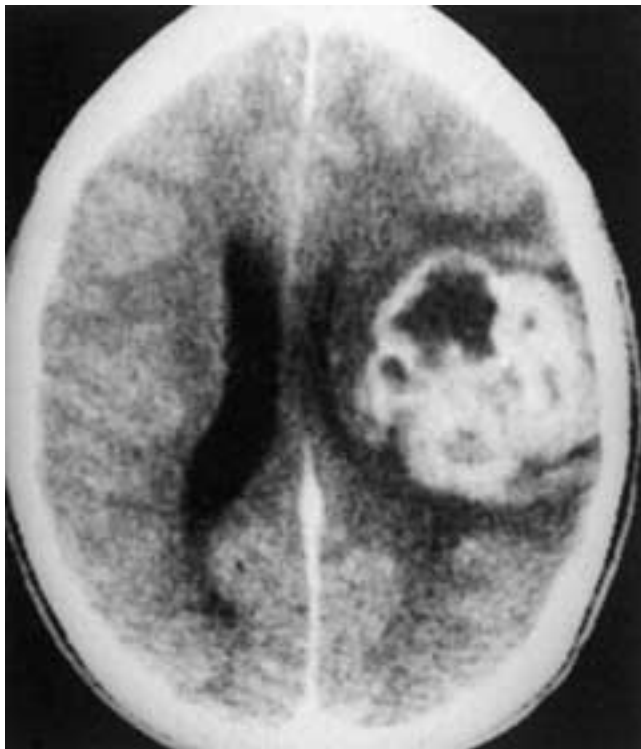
Glioblastoma multiforme. Axial CT image after injection of contrast medium shows marked enhancement of an irregular mass in the left frontal parietal region. The body of the left lateral ventricle is compressed.
